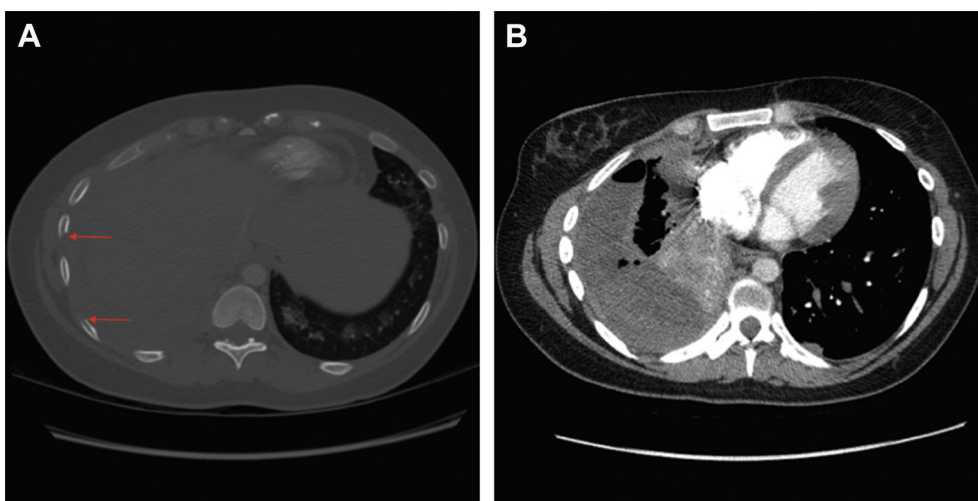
A, B, CT pulmonary angiogram was negative for pulmonary embolism. However, it demonstrates pleural thickening and nodularity with extension into the intercostal spaces (A) and associated osseous destruction (arrows in A). A large right-sided pleural effusion with significant atelectasis of the right middle and lower lobes is shown (B).
